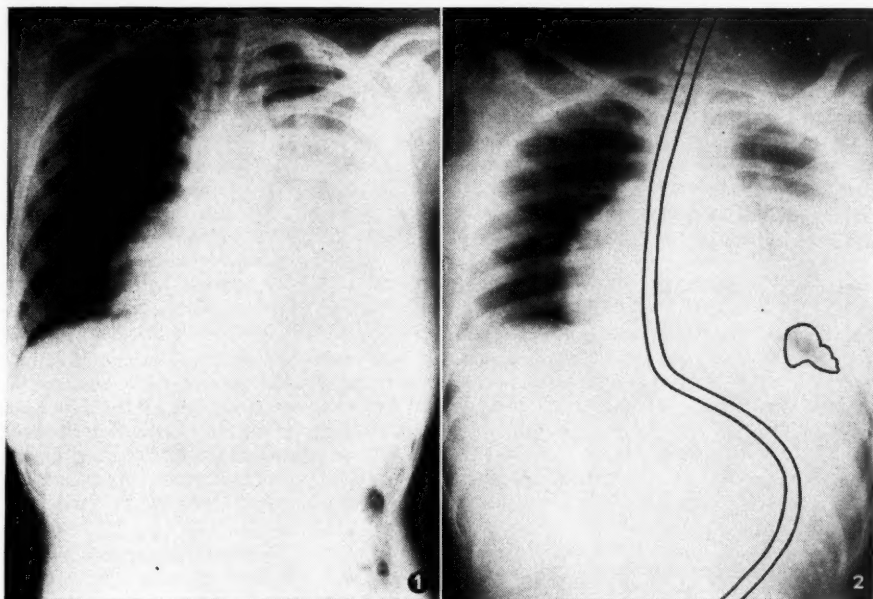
Admission radiograph showing a massive left pleural effusion with displacement of the heart and the mediastinum to the right.
